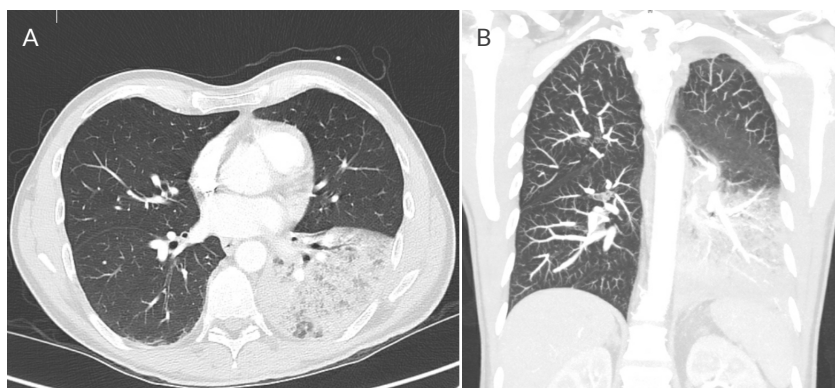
Computerised tomography (CT) scan of the chest obtained upon admission showing left lower lobe lung consolidation consistent with pneumonia in A) cross-sectional and B) coronal view.
